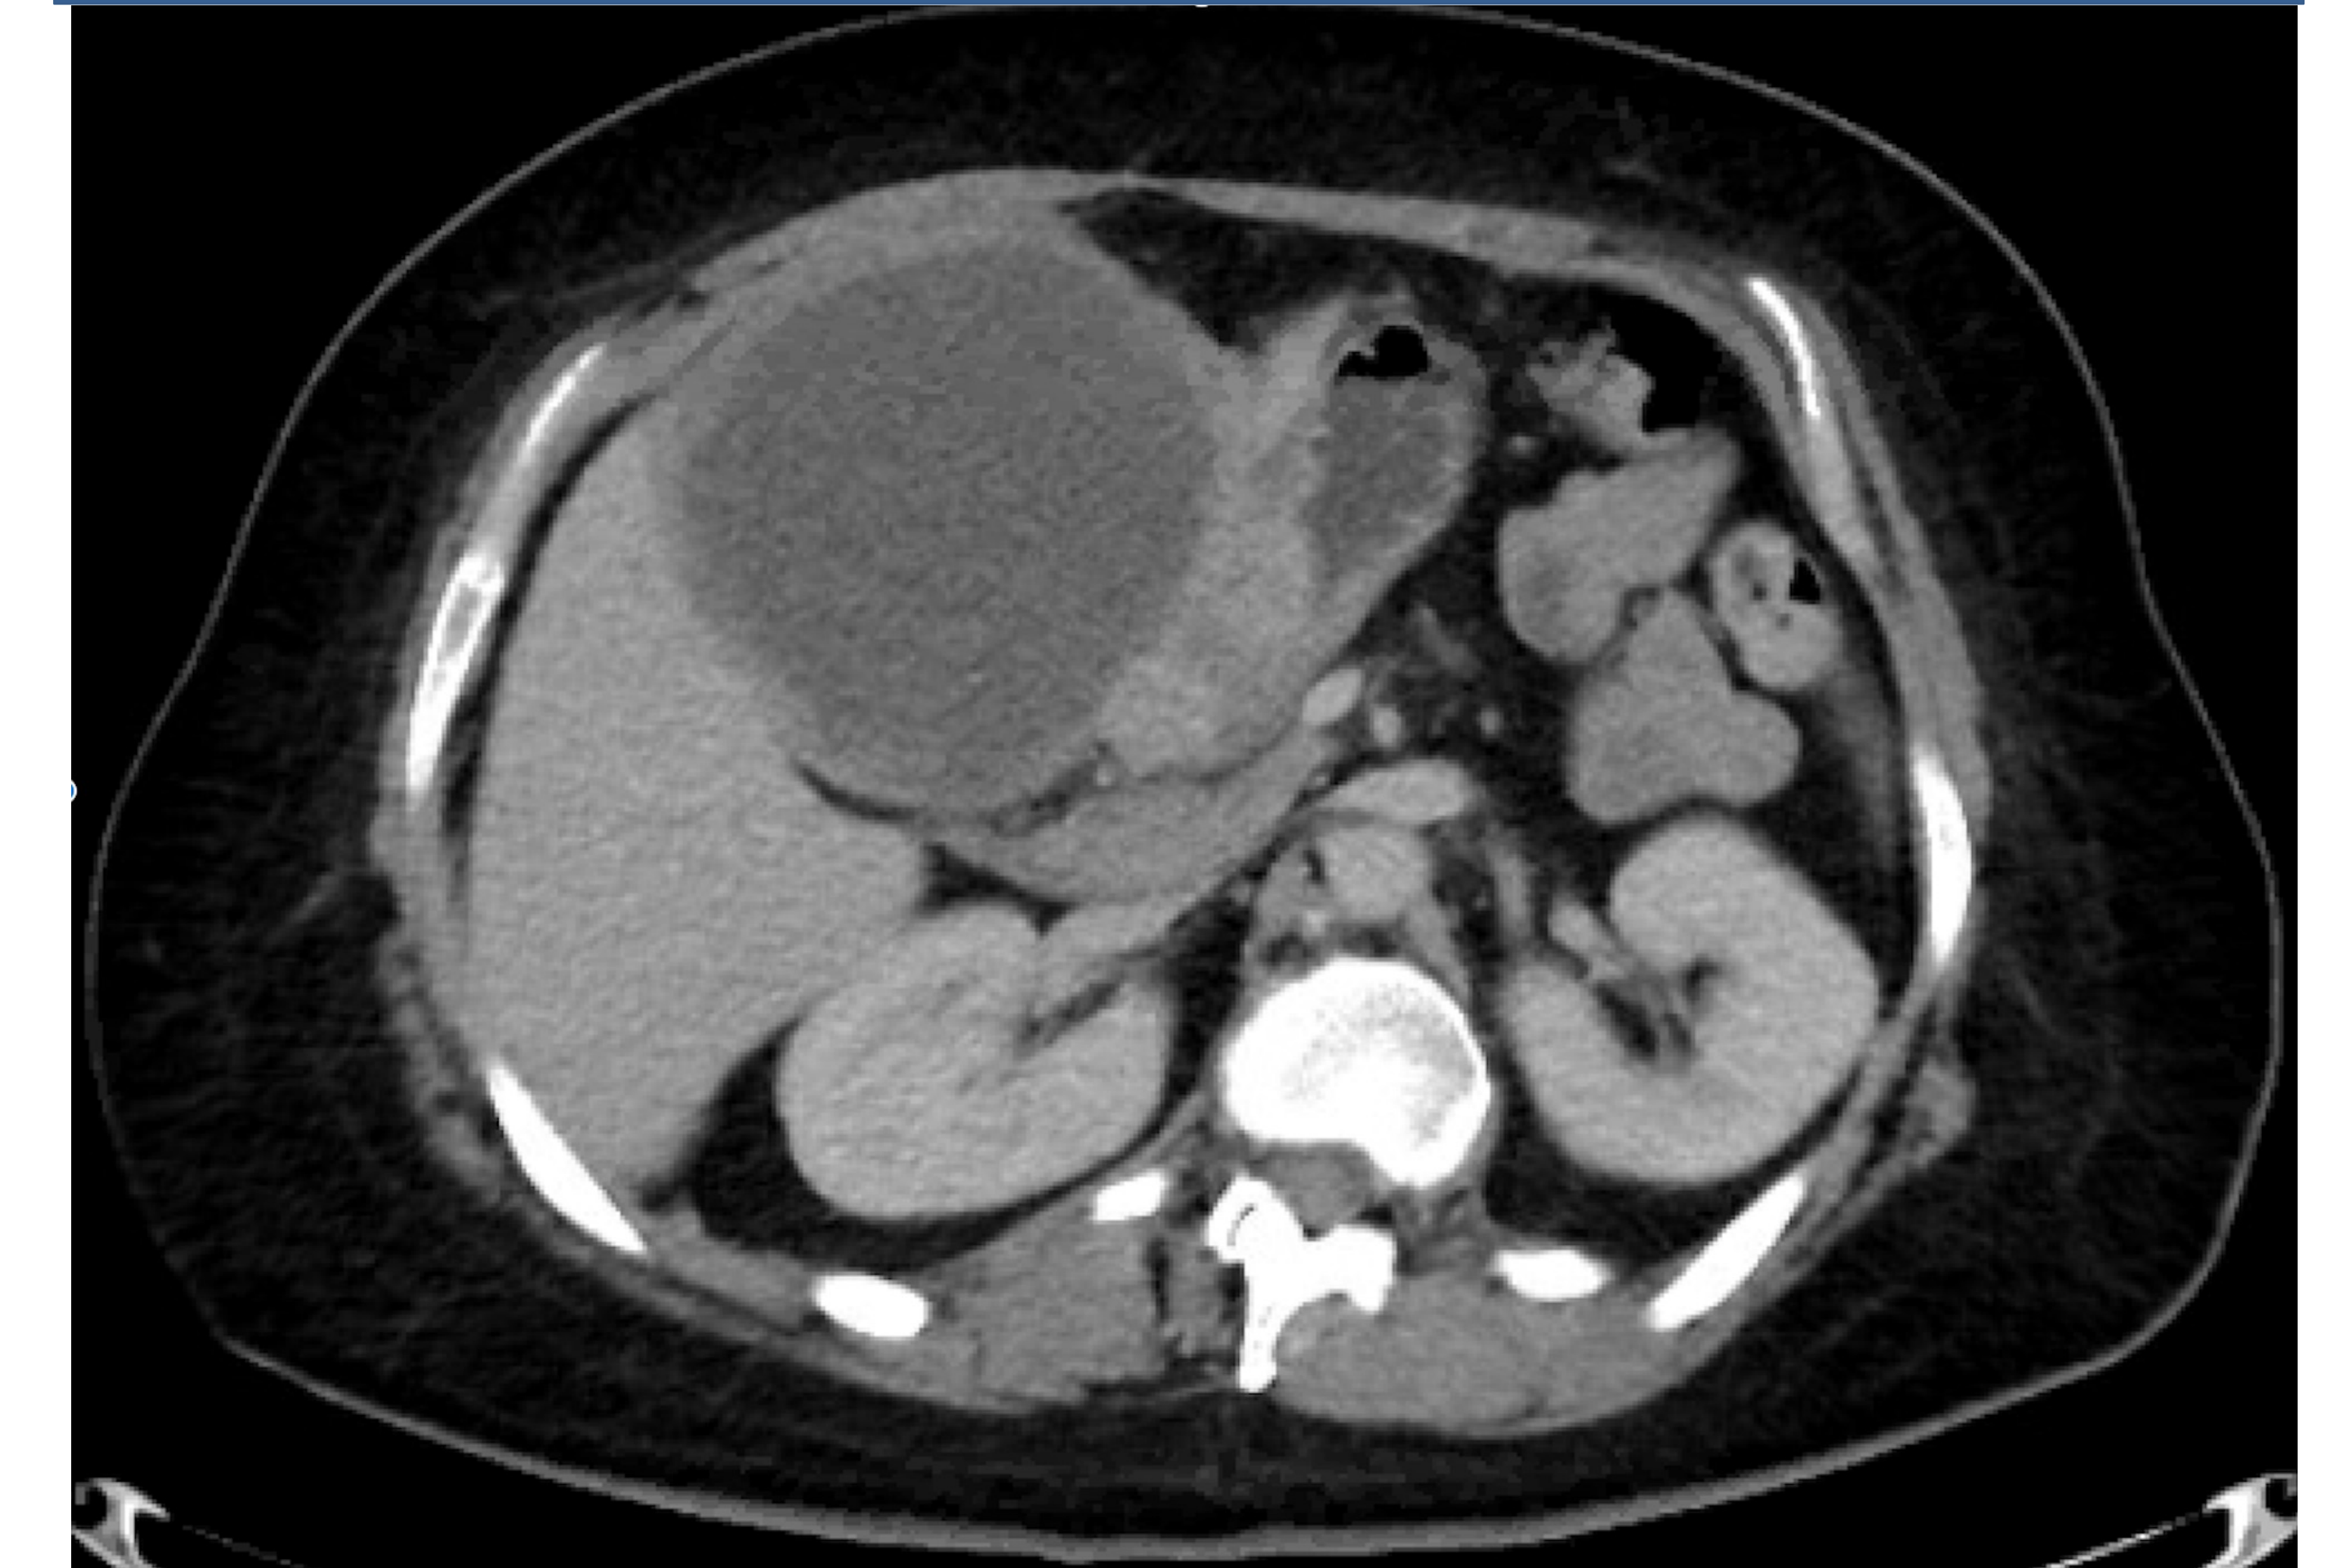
CT of abdomen with contrast: a 14.3 x 11.6cm mass at the right hepatic lobe.
